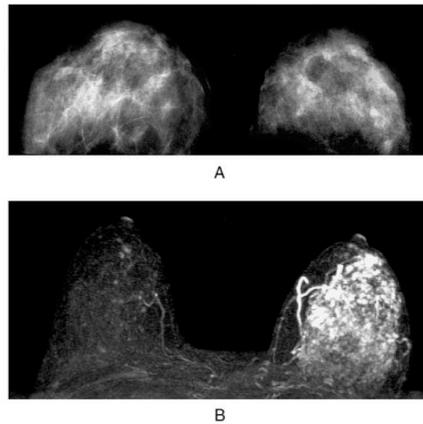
Comparison of a mammogram (A) and an MRI (B) of the same individual (Wright, 2005).
